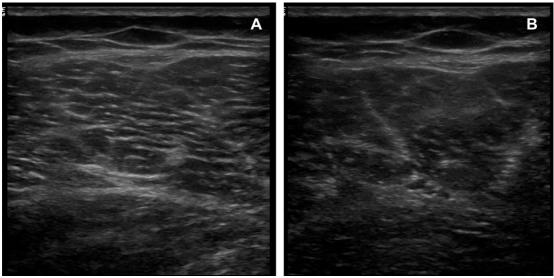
B mode ultrasound imaging of the vastus lateralis muscle. (A) Without artefact; (B) with anisotropy artefact.
